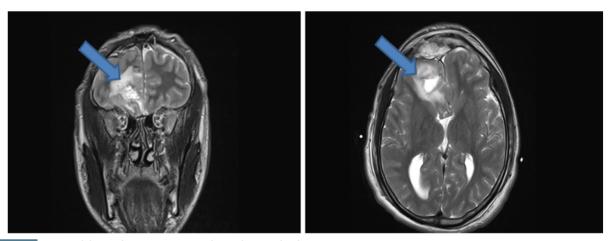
Ruptured dermoid cyst on contrast-enhanced T2 weighted MR imaging
